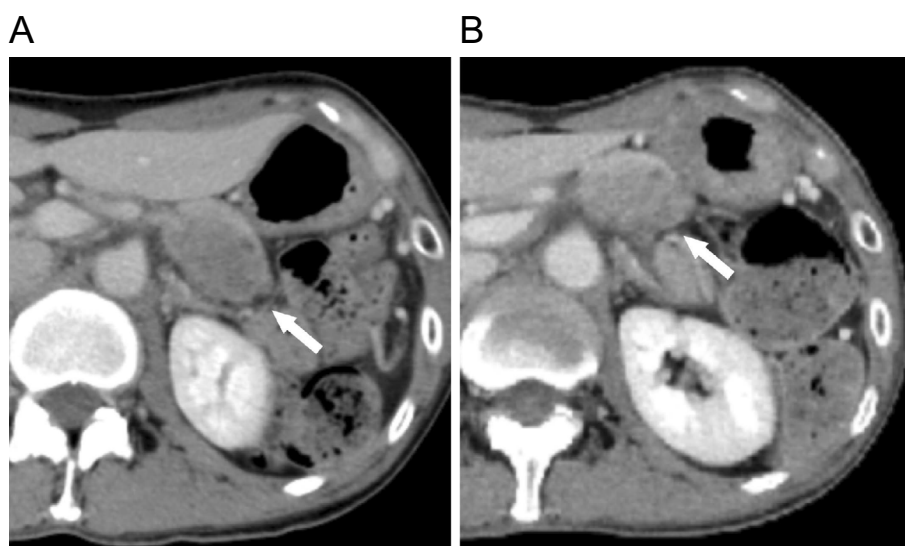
Contrast-enhanced computed tomography (CT) before and after chemotherapy. (A) The maximum diameter of the pancreatic ductal carcinoma was 37 mm on contrast-enhanced CT before chemotherapy (arrow). (B) The maximum diameter of the pancreatic ductal carcinoma was 30 mm on contrast-enhanced CT after chemotherapy (arrow).
